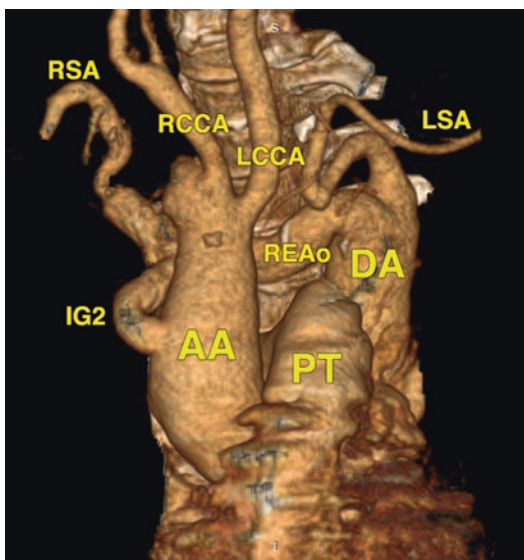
Postoperative three-dimensional computed tomography reconstruction of the thoracic aorta (AA ascending aorta, PT pulmonary trunk, REAo retroesophageal aorta, DA descending aorta, RCCA right common carotid artery, LCCA left common carotid artery, RSA right subclavian artery, LSA left subclavian artery, IG2 second interposition graft)
